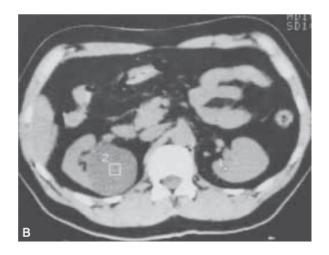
Simple renal cyst (CT scan) (mass in the left kidney) (Campbell-Walsh Urology, chapter 131, Renal Dysgenesis and Cystic Disease of the Kidney).
